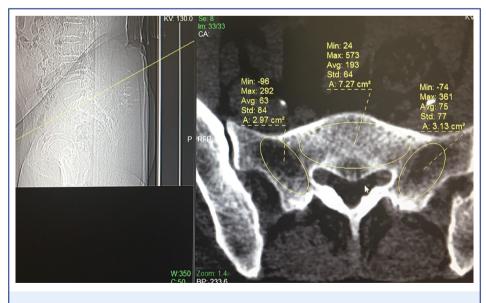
Hounsfield unit measurement with computed tomography. When the largest possible elliptical area excluding cortical edges is drawn using the Picture archiving and communication system system, the system automatically calculates the Hounsfield unit value
